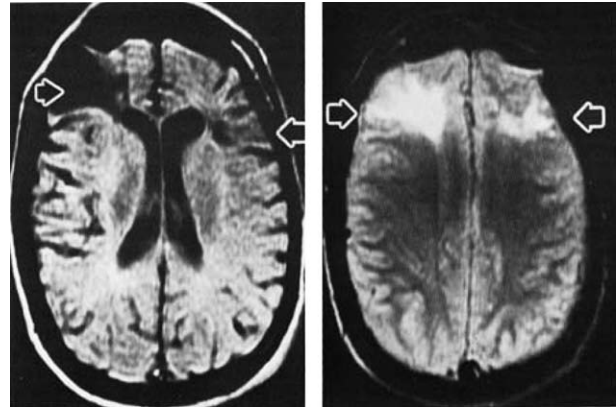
Brain MRI scan showing residual post-traumatic lesions in MH, acquired at 4 years of age. Reprinted from *Brain*, 113, Price, B.H. et al., The comportmental learning disabilities of early frontal lobe damage, 1383–1393, 1990, with permission from Oxford University Press.
